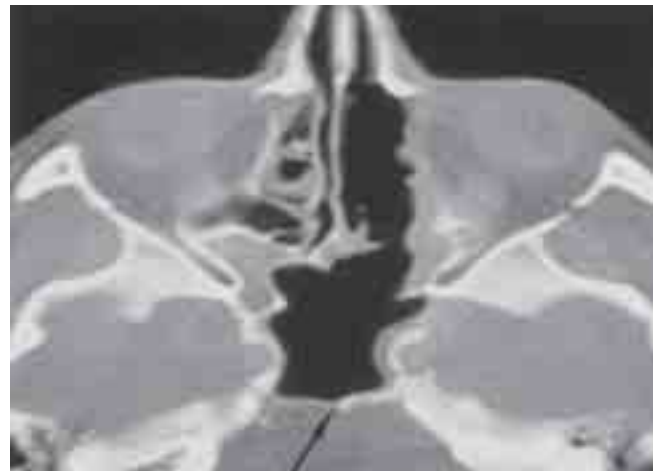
Patient B: Post-operative axial CT scan view after removal of fungus ball showing clear cavities.
